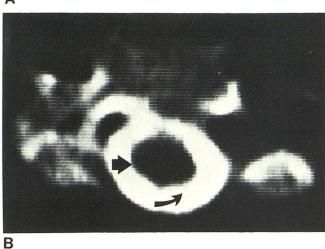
A, Spinal cord metrizamide study, window center (level) of 250, window width of 1. These are optimum levels for cord measurement. Metrizamide, average CT number (curved arrow) was 470. Spinal cord (arrow), average CT number was 30. Mean between 470 and 30 is 250. Most accurate window width is narrow window width of 1. B, With appropriate center (level) setting, varying window width has no appreciable effect upon object size. Wider window improves aesthetics of image.
